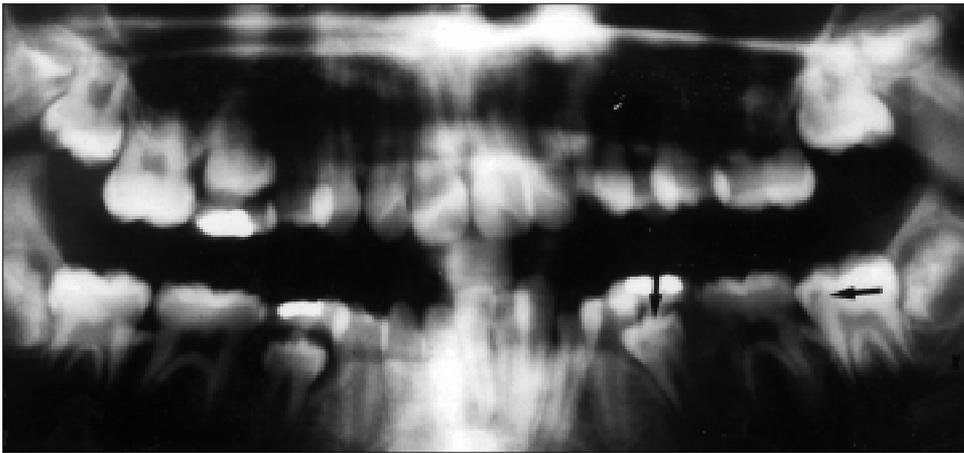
Orthopantomogram of the subject in Fig 1 at age 11 yrs, confirming the presence of radiolucencies (arrowed) within the crowns of the unerupted mandibular left second premolar and second molar. These are likely to be pre-eruptive intracoronaral resorptive defects.
